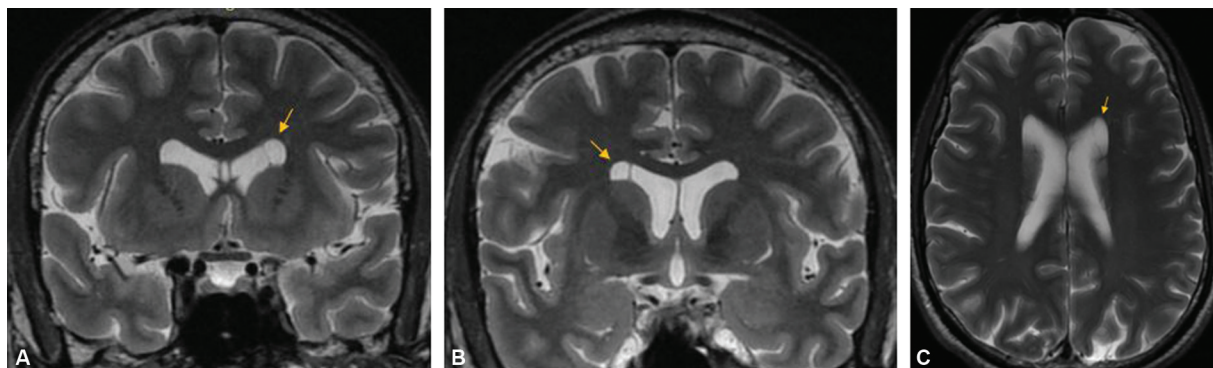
(A and B) Magnetic resonance imaging (MRI) T2-weighted coronal images; arrows depicting a well-defined, T2 hyperintense subcentimeter, cystic areas adjoining the superolateral margins of frontal horns and body of the lateral ventricles, bilaterally. (C) MRI T2-weighted axial image; arrow showing a T2 hyperintense cyst anteriorly adjoining the superolateral margins of frontal horns and body of the lateral ventricles.
